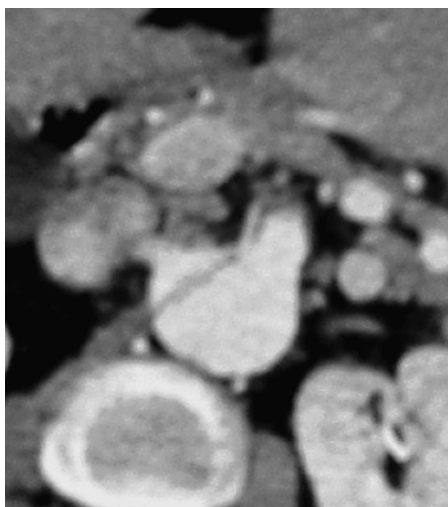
CT scan depicting dissection flap in SMA
